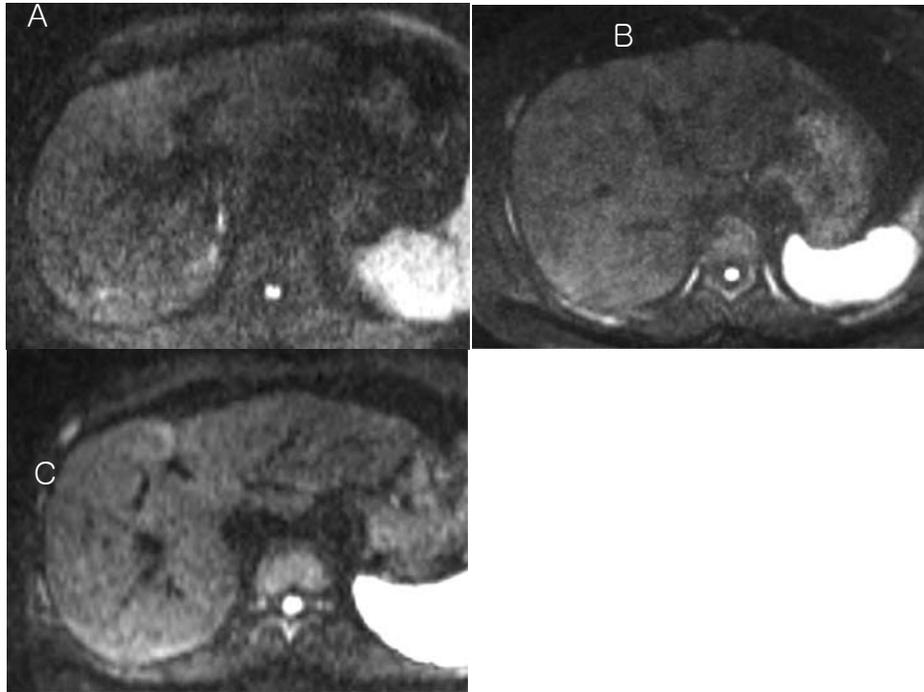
Representative examples of diffusion-weighted MR images of $b=800 \text{ mm}^2/\text{s}$ with breath-hold, free-breathing, and respiratory-triggered methods in three different patients.
